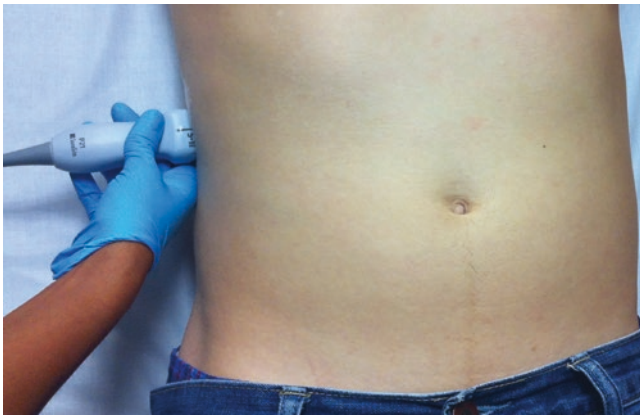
Ultrasound probe position for visualizing the right kidney. To obtain sagittal views, point the probe marker toward the patient's head, and scan in the posterior axillary line at the level of the costal margin. Sweep both anterior-posterior and rostral-caudal to visualize the entire kidney. To obtain transverse views, point the probe marker toward the patient's posterior and scan in the posterior axillary line at the level of the costal margin. Sweep both rostral-caudal and anterior-posterior to visualize the entire kidney. (Image courtesy of Bret Nelson.)
